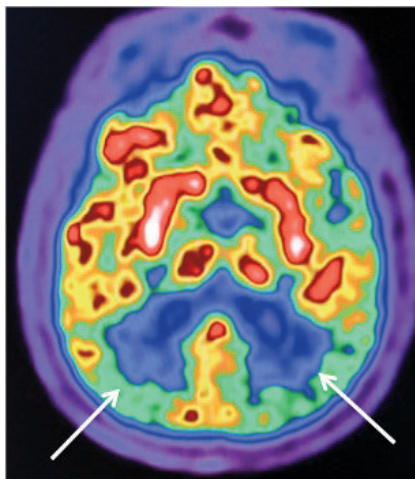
Transaxial <sup>18</sup>FDGPET brain revealing bilateral predominantly occipital hypometabolism (arrows) in a patient with DLDB.
